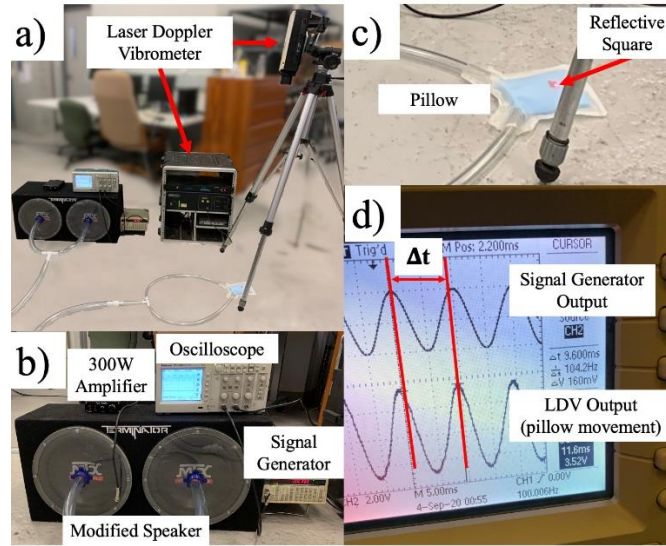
a) Full laser doppler vibrometry setup for frequency response testing of the original MRE actuator design, b) the actuator full active driver setup with labeled components, c) the pillow and reflective square for measuring end effector vibration, and d) measuring the amplitude and time delay between signal output and pillow vibration.
